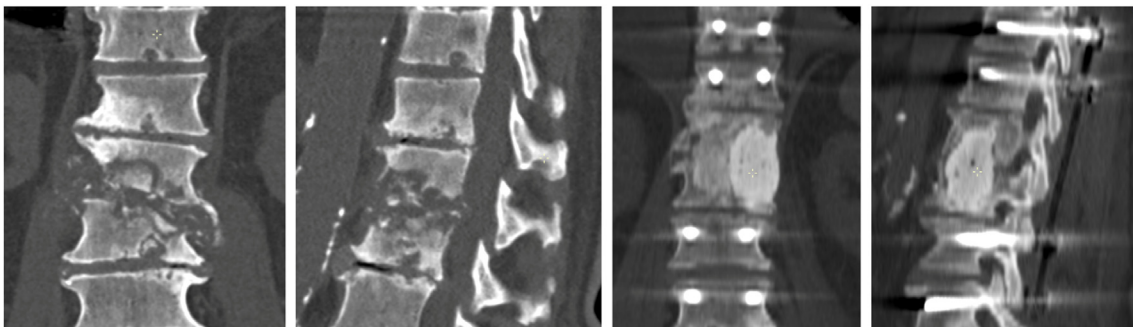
Example of spinal instability (L1-L2) and conservative treatment failure. This 80-year-old man had diabetes and was treated conservatively during 42 days before going to surgery. A posterior approach was performed to stabilize the spine, then lumbotomy was used to remove infected tissue. This left a large gap, that was filled with bone chips (right side) and cement (left side), as on the CT scan at 8 months. Gap height was 46 mm. Patient improved but died one year later of renal insufficiency.
